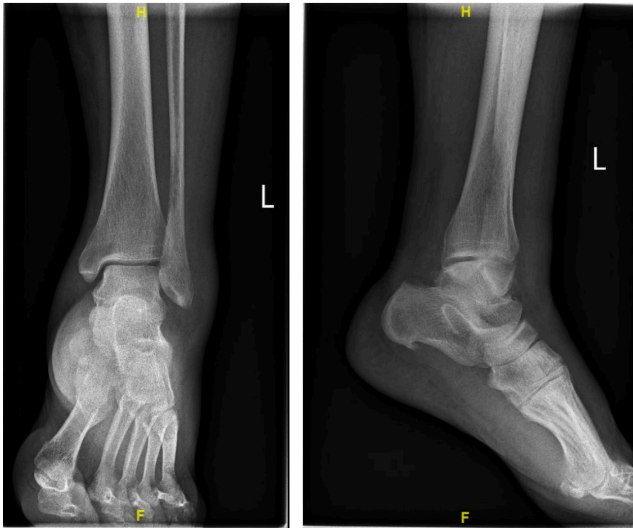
AP and lateral radiographs at patient's initial presentation demonstrate a lytic meta-diaphyseal lesion with erosion of the posterior cortex.
